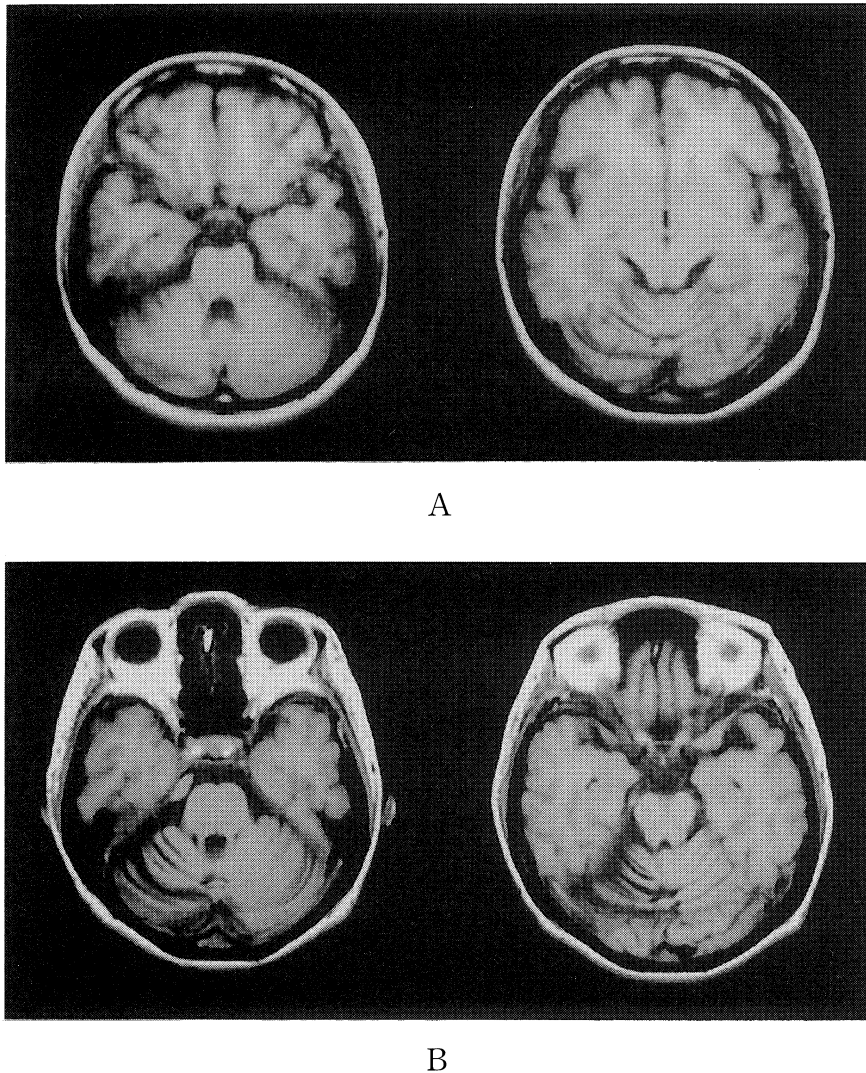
Magnetic resonance imaging (TR/TE=500/30). A: MRI in 1991, one year after the onset of cerebella ataxia. B: MRI in 1999 after onset of stiff-person syndrome. Cerebellar atrophy had developed.
